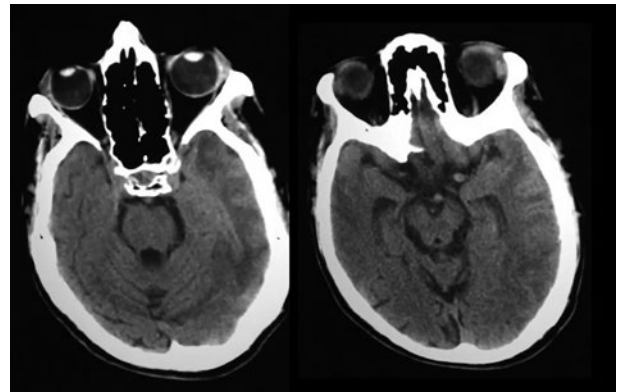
Axial computed tomography with cortical and subcortical white and gray matter changes with lack of specific vascular territory in temporal and occipital left hemisphere.
